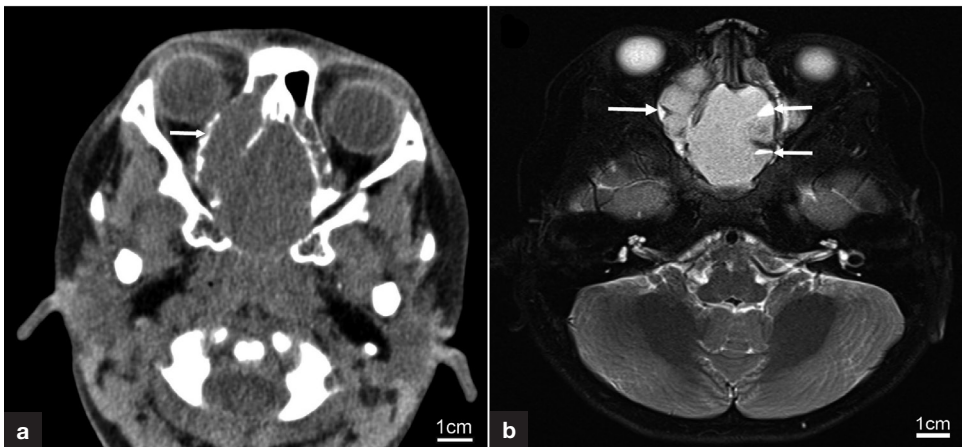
a. Axial computed tomography scan. The mass is seen in the right ethmoid and sphenoid sinuses, squeezing the medial rectus muscle and optic nerve, with papyraceous lamina remodelling (arrow). b. Axial magnetic resonance imaging scan. The lesion was hyperintense in T2-weighted scans, with no typical fluid–fluid level (arrows).
